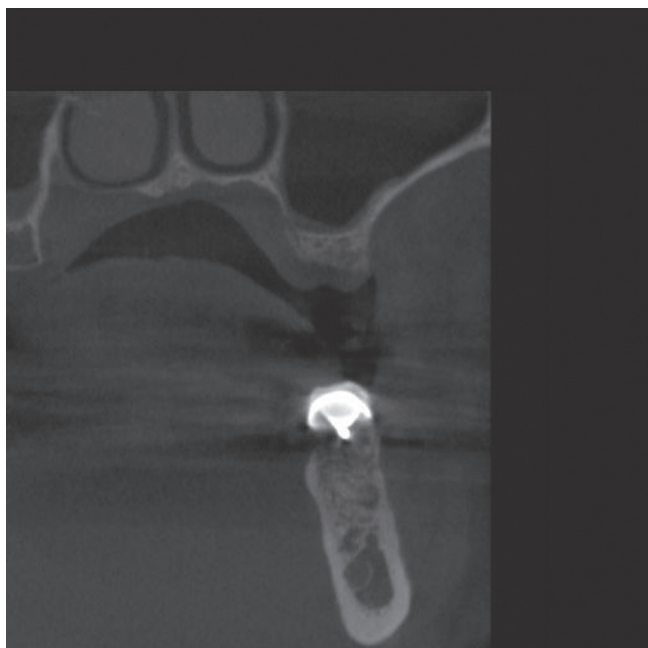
Pre-treatment CBCT scan.
